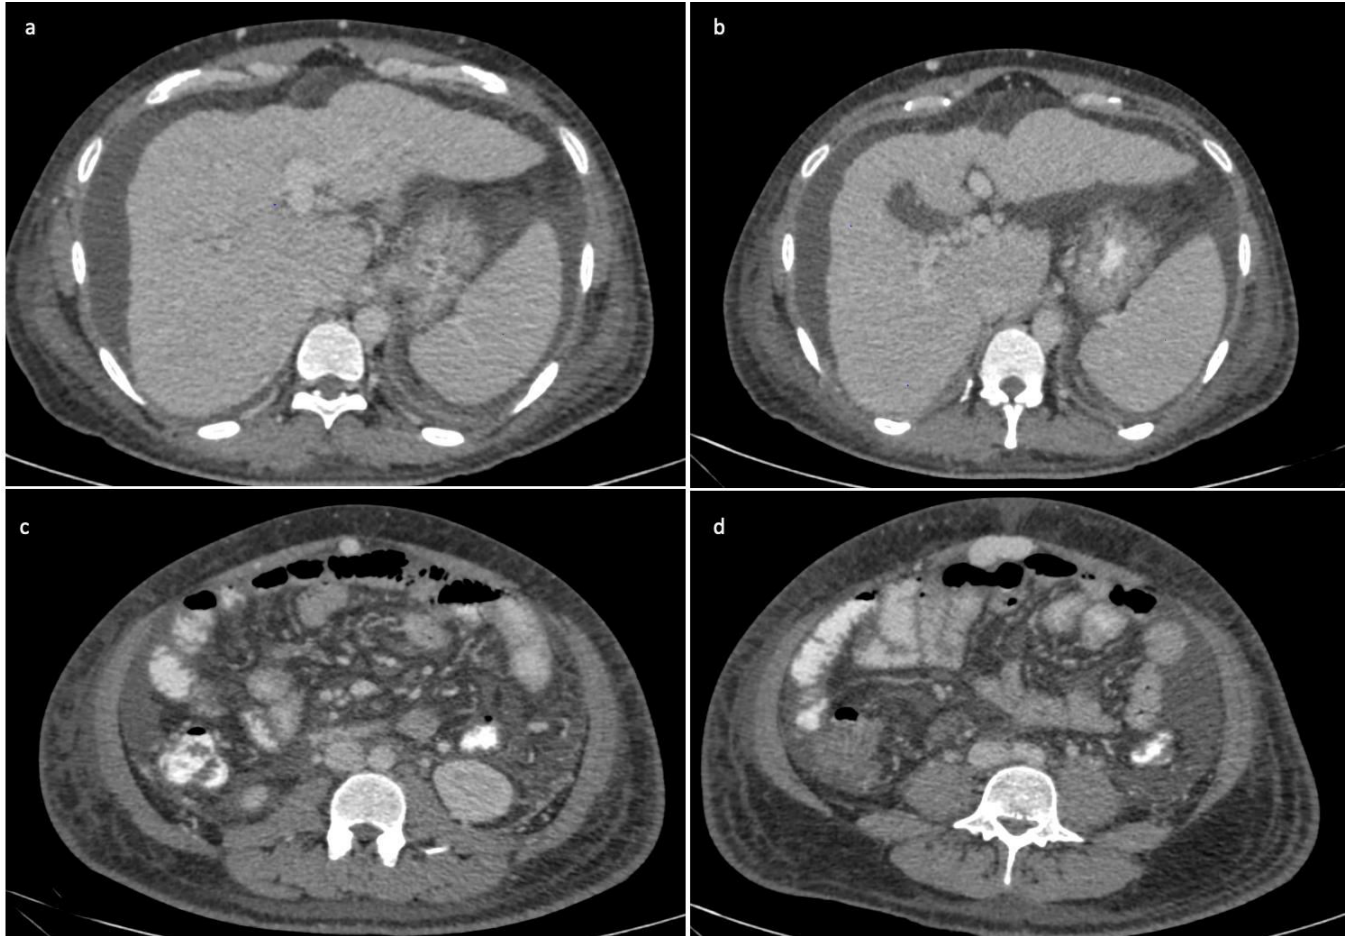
& Figure 5b: Axial CT abdomen post contrast images reveal shrunken right lobe of liver with surface nodularity and ascites. Multiple periportal collaterals are also noted.
